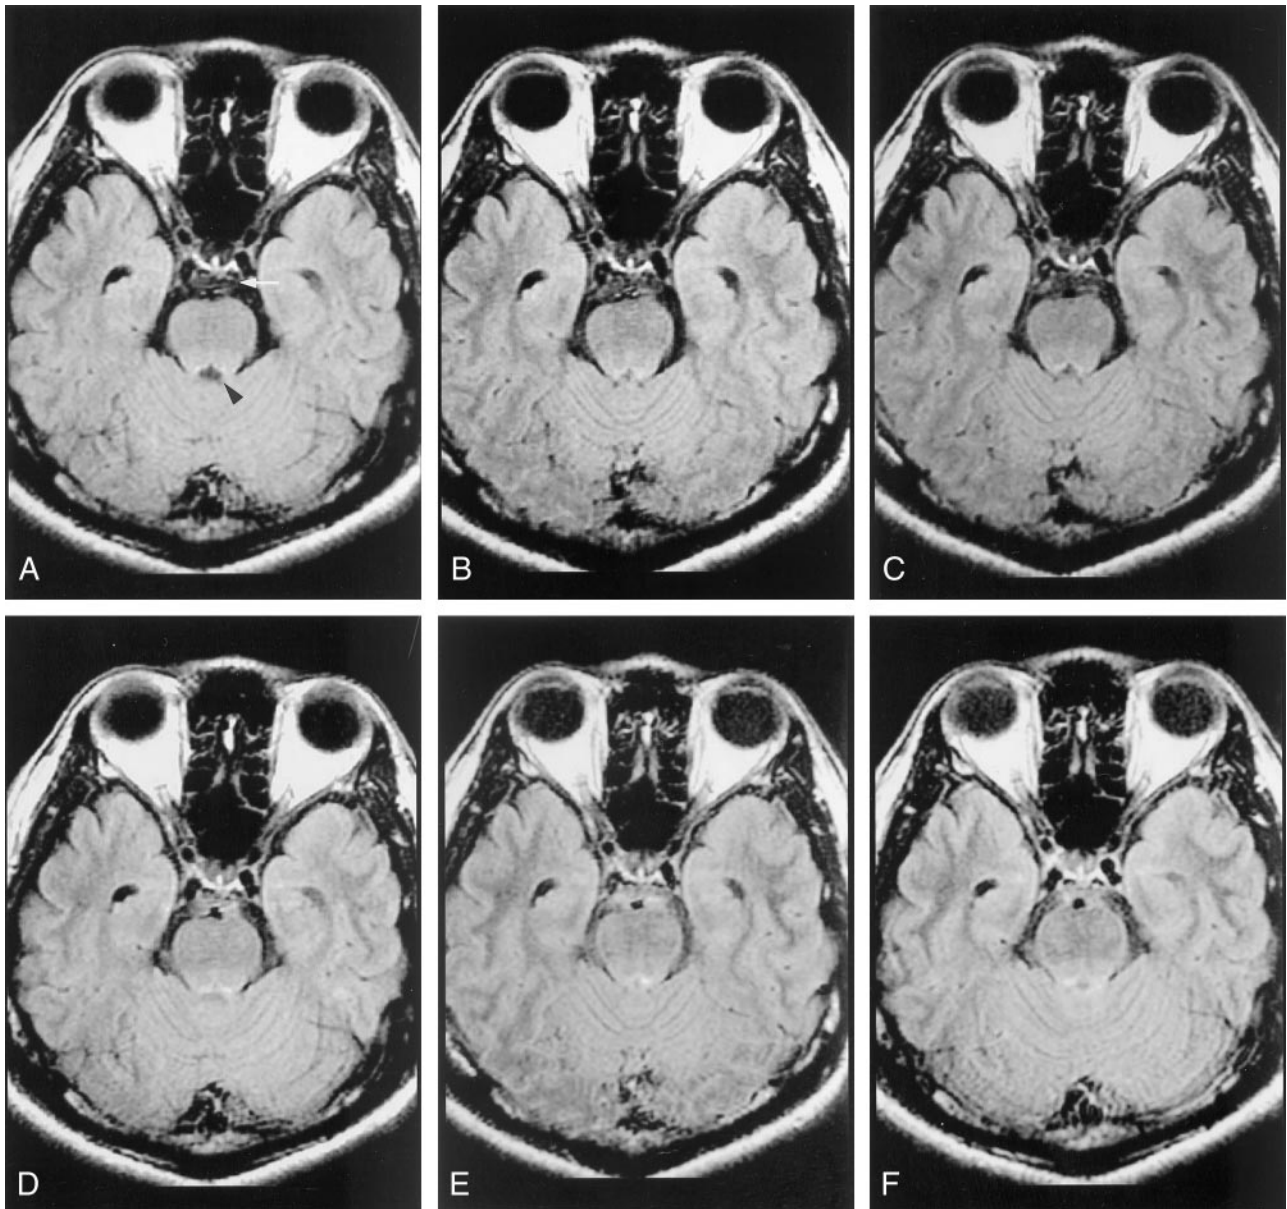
Comparison of images parameters in terms of high-intensity CSF artifacts on fast-FLAIR images obtained in a 37-year-old healthy male volunteer (volunteer 5).
